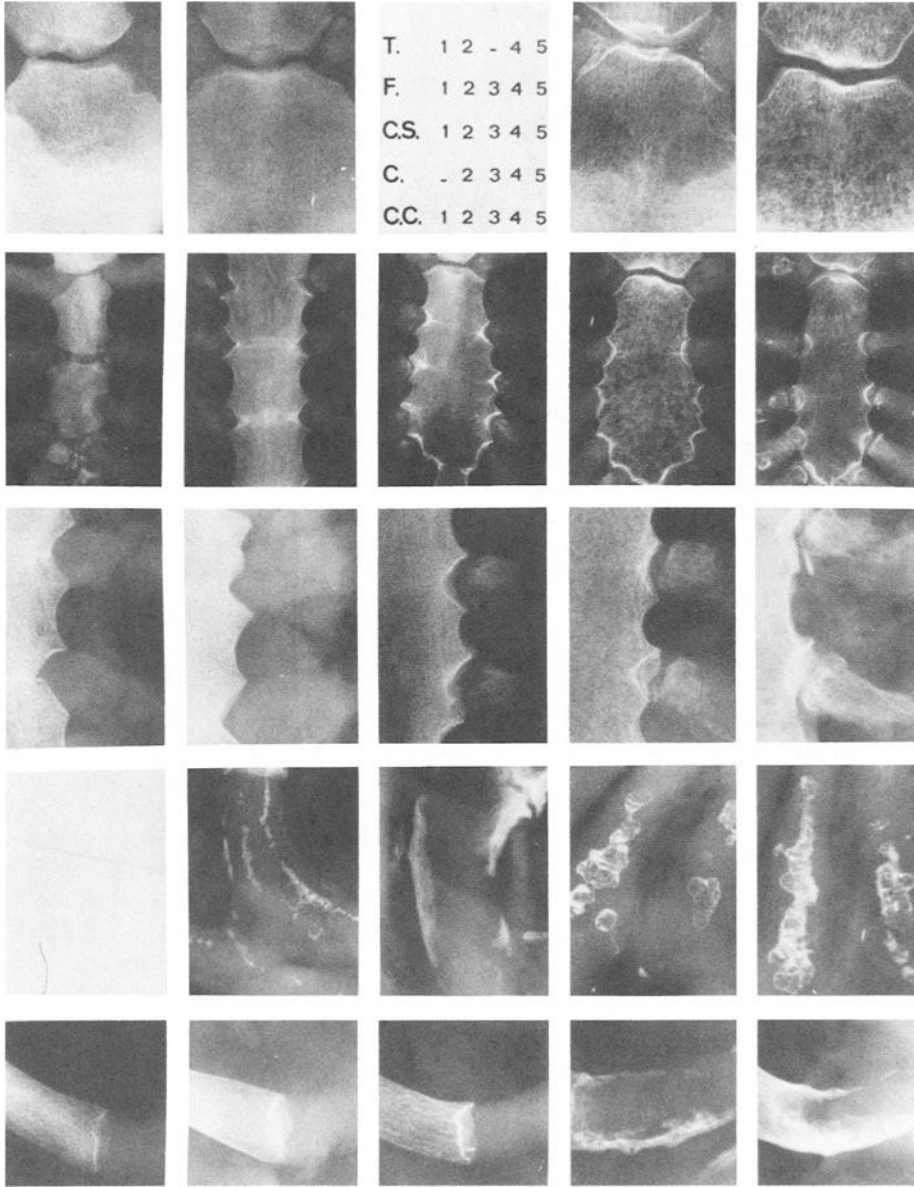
Photographic template used for feature assessment of chest plate X-ray films. First stage of cartilage mineralization is not shown for it corresponds to the absence of mineralization. Stage 3 of bone demineralization lies inbetween bone density of Stage 2 and Stage 4. T: bone demineralization, F: sternal fusion, C.S.: cartilage-to-sternum attachment, C: cartilage mineralization, and C.C.: cartilage-to-rib attachment.
